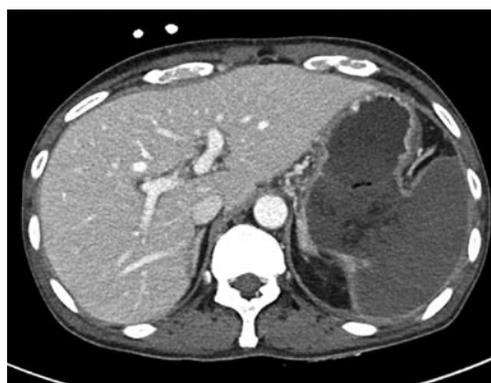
On an axial computed tomography image taken after chemotherapy, a huge fistula was shown between the gastric lumen and the spleen. The spleen was totally infarcted.
